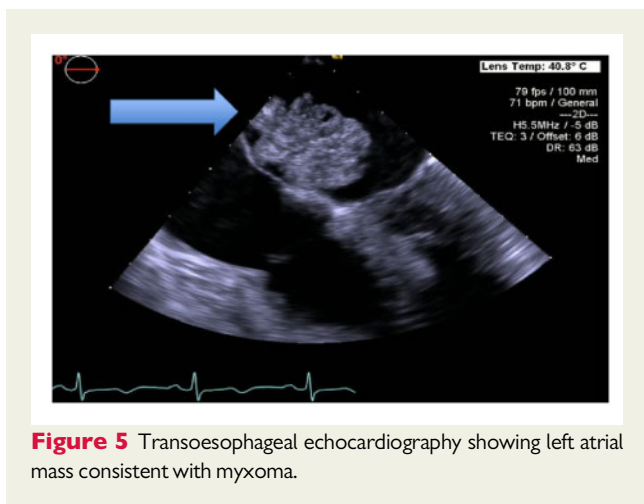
Transoesophageal echocardiography showing left atrial mass consistent with myxoma.
